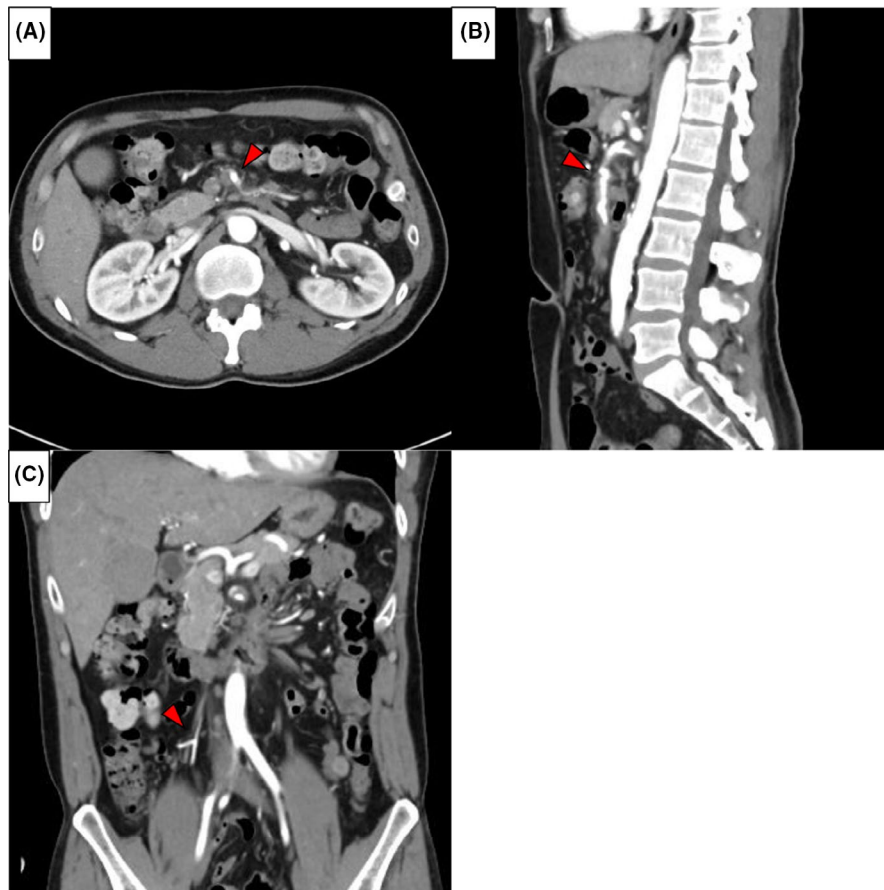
Follow-up CT after 7 days. Enhanced abdominal CT after 7 days admission shows the false lumen of the SMA (A, B, red arrow) and the ileocolic artery (C, red arrow) are smaller and the true lumen is slightly more open than in the initial CT images
